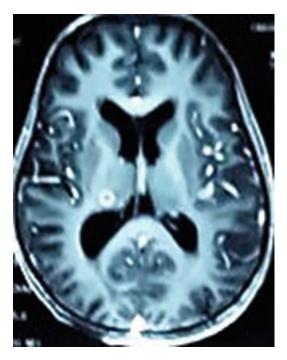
Tuberculomas without significant hydrocephalus in a patient with military TB. Axial post-contrast MR images showing tuberculomas with normal-sized ventricles
